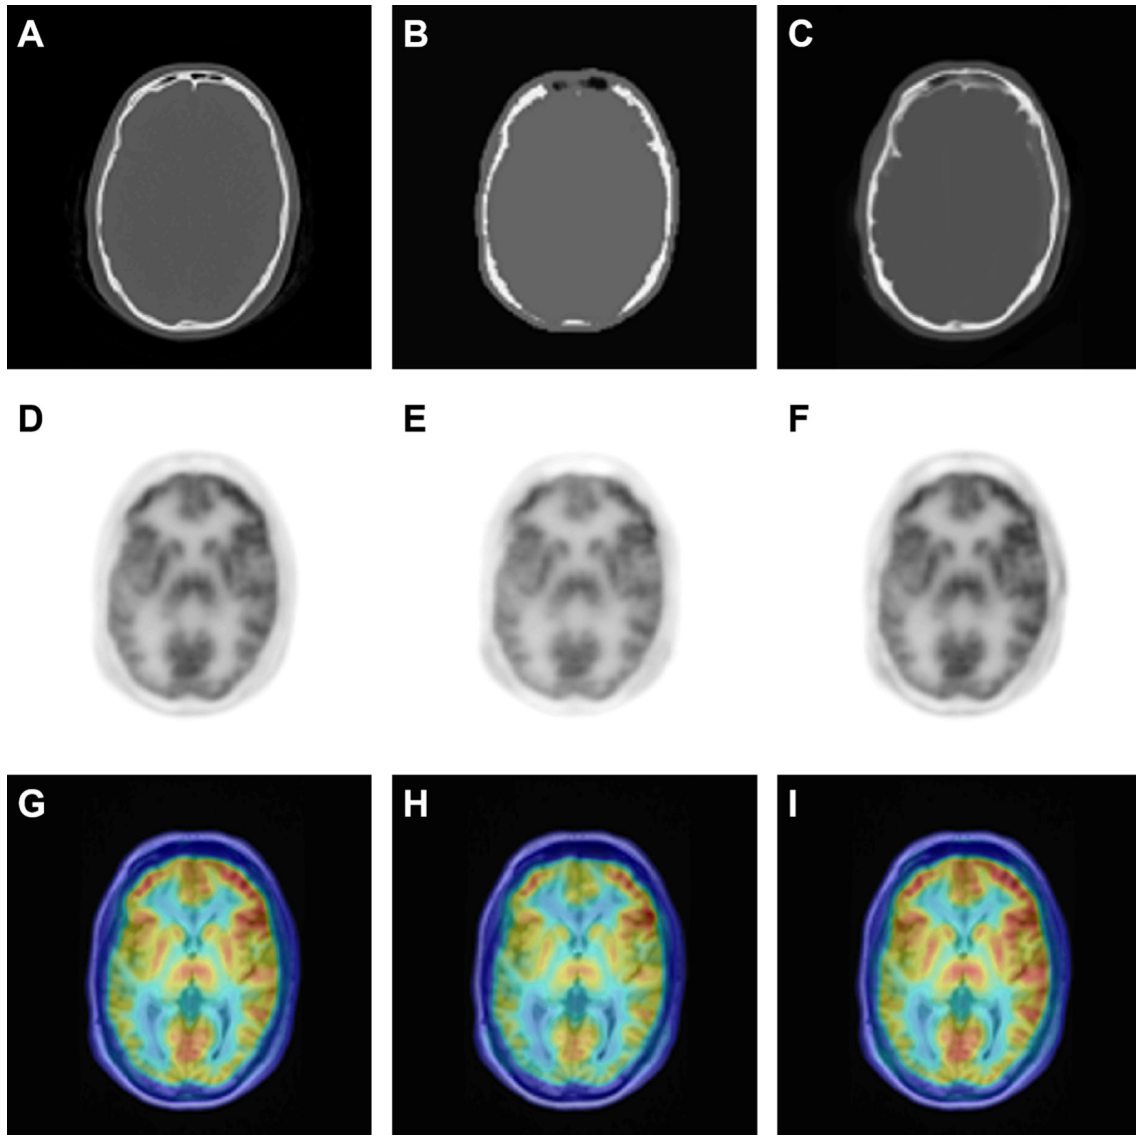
Axial slices of AC maps of the head and neck obtained from a real CT (A), and from MR images with a method based on segmentation by classes (B) and with a pseudo-CT synthesis method (C), as well as the 18F-FDG PET study images corrected with each of these methods (D-F) and the representation of each of these PET images fused with an anatomical MR T1 image of the patient (G-I). From Torrado-Carvajal et al. [81].
